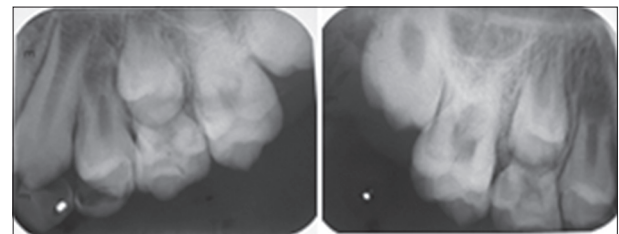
Radiographs of right and left molars
